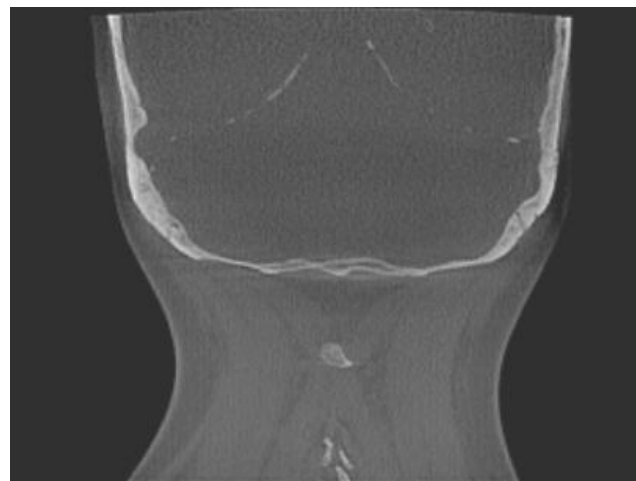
Coronal CBCT section of the skull identifying a linear, crescent-shaped intracranial calcification of the falx cerebri
